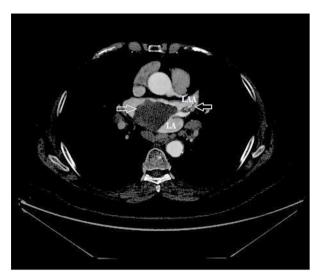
Contrast-enhanced computed tomography. Thrombus
